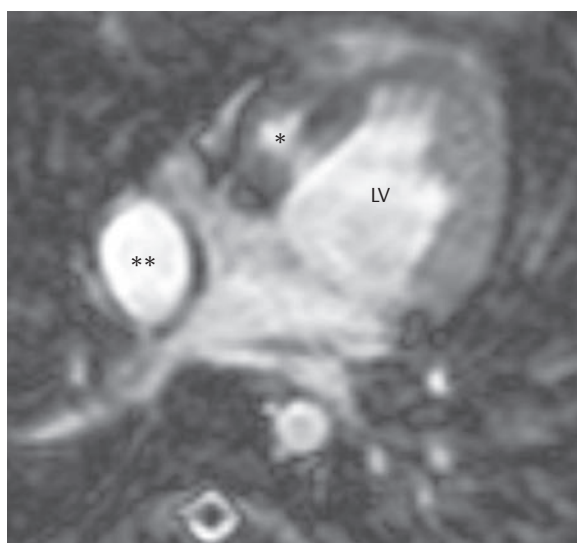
DILV in a case of tricuspid atresia. Seven-year-old male patient with extracardiac Fontan tunnel (double asterisk) and DILV accompanied by tricuspid atresia. SSFP cine MRI, axial section. The asterisk indicates the rudimentary right ventricle. LV = left ventricle
